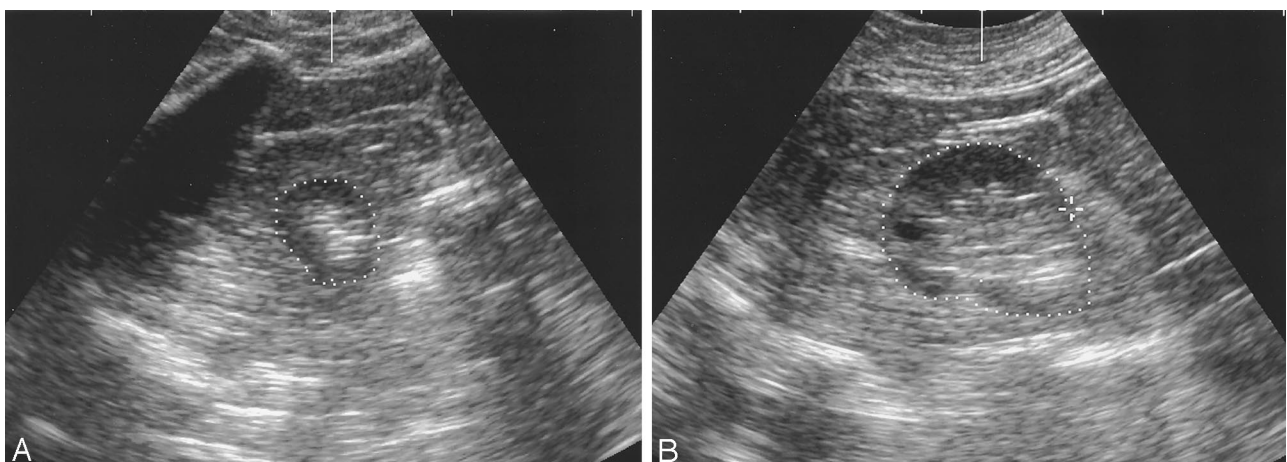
A 53-year-old male patient with 3D ultrasound of right kidney. (A) Ultrasound image in the axial plane at the level of the upper pole. Note: dots indicate manually delineated contour of the kidney. (B) Ultrasound image in the axial plane at a level between the hilum and the upper pole. Note: dots indicate manually delineated contour of the kidney.
